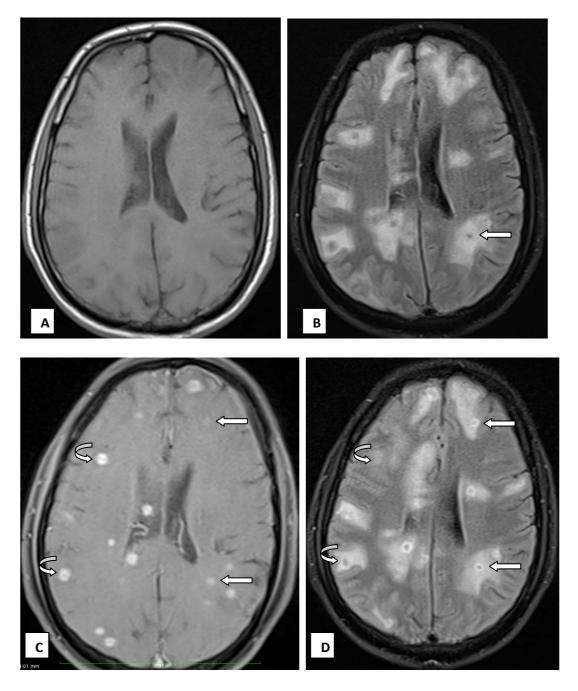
A case of 54-year-old male with disseminated tuberculoma. MRI axial images: (A) T1WI reveals no abnormality. (B) T2 FLAIR revealed multiple, well defined, subcentimetric hypointense lesions with perilesional edema. (C) T1 FS PC & (D) T2 FLAIR PC images demonstrated multiple, ring enhancing lesions with perilesional edema. In comparison with T1 FS PC sequence, T2 FLAIR PC sequence shows better contrast enhancement of few lesions and perilesional edema (Arrow mark). In comparison with T2 FLAIR PC sequence, T1 FS PC sequence shows better contrast enhancement of few lesions (Curved arrow).
